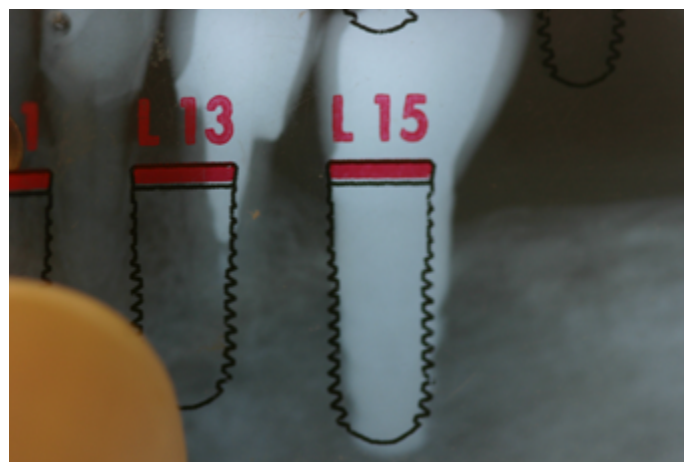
Superimposition of a measuring plastic transparent sheet on the periapical film in region #36.*
